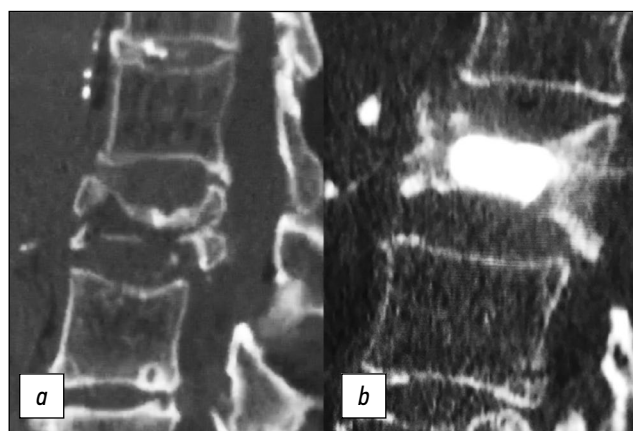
(a): CT scan: Sagittal reconstruction of a complex vertebral fracture. (b): Post-operative CT control. Vessel-X is perfectly placed without BFM leakage.
